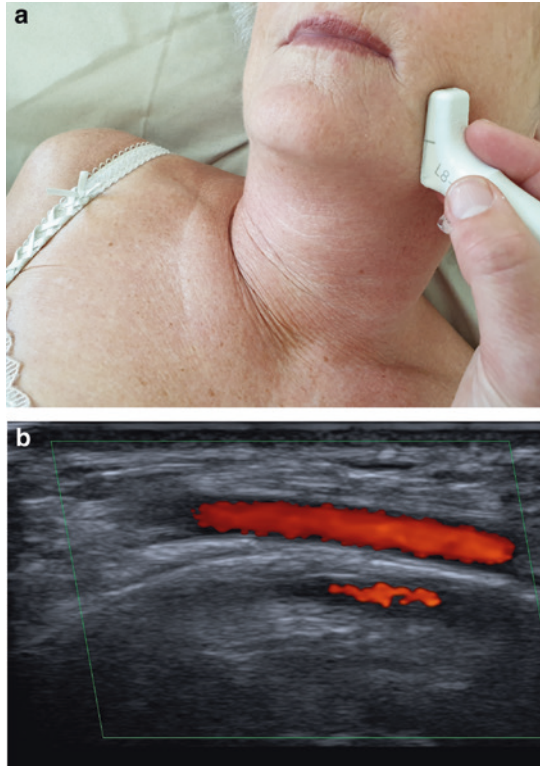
Examination of the facial artery: a recommended position of the transducer b ultrasound image, longitudinal view
